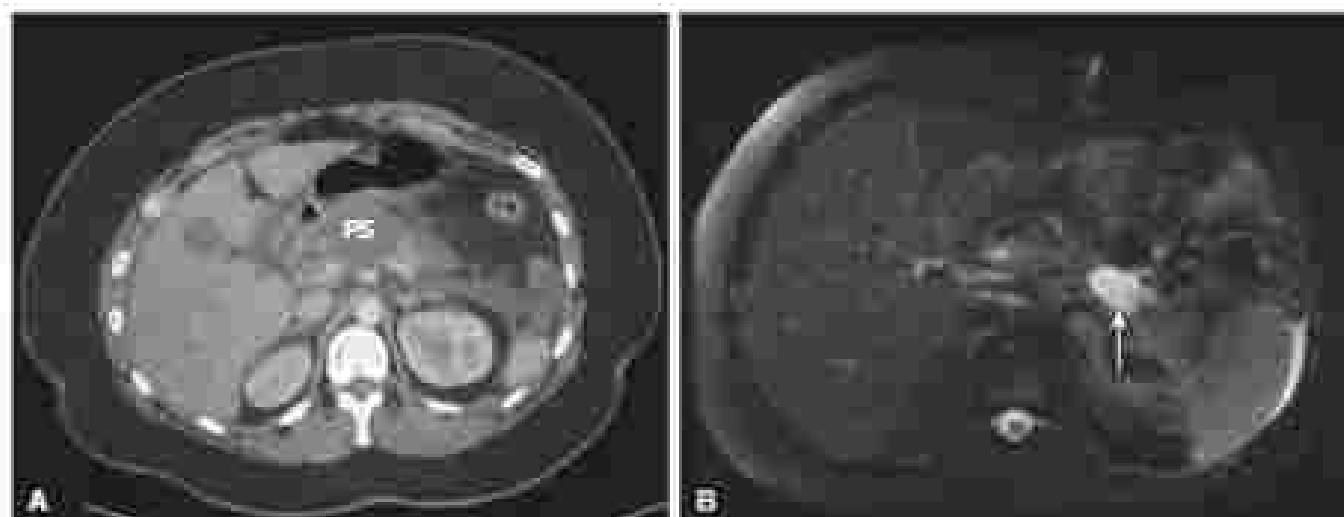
(A) Contrast-enhanced computed tomography scan demonstrates a small pseudocyst in cross-section in the mid-body of the pancreas. (B) T2-weighted magnetic resonance imaging with T2-weighted imaging shows fluid and homogeneously enhancing tissue (pseud) in the distal pancreatic body consistent with a pseudocyst. PS, pseudocyst.
